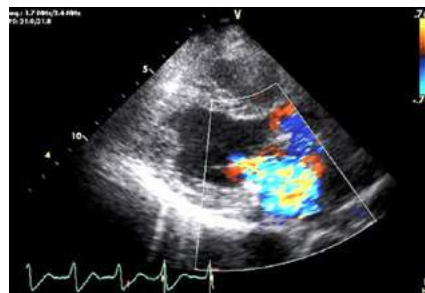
Transthoracic parasternal long axis 2-D echocardiogram with Colour Doppler showing the severe mitral regurgitation secondary to incomplete closure of the mitral leaflets.
